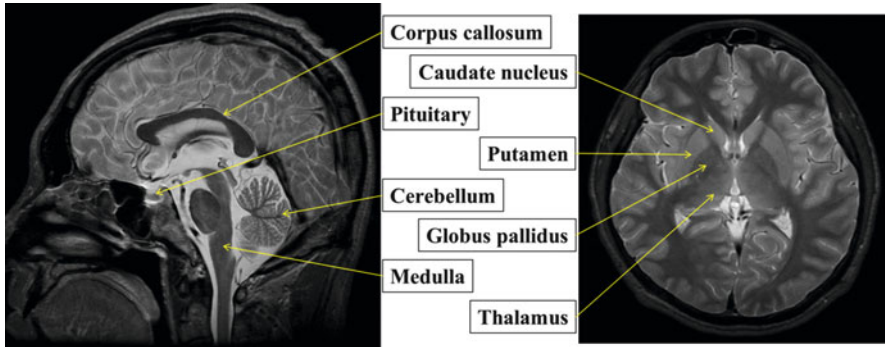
MRI anatomy of the normal adult human head
